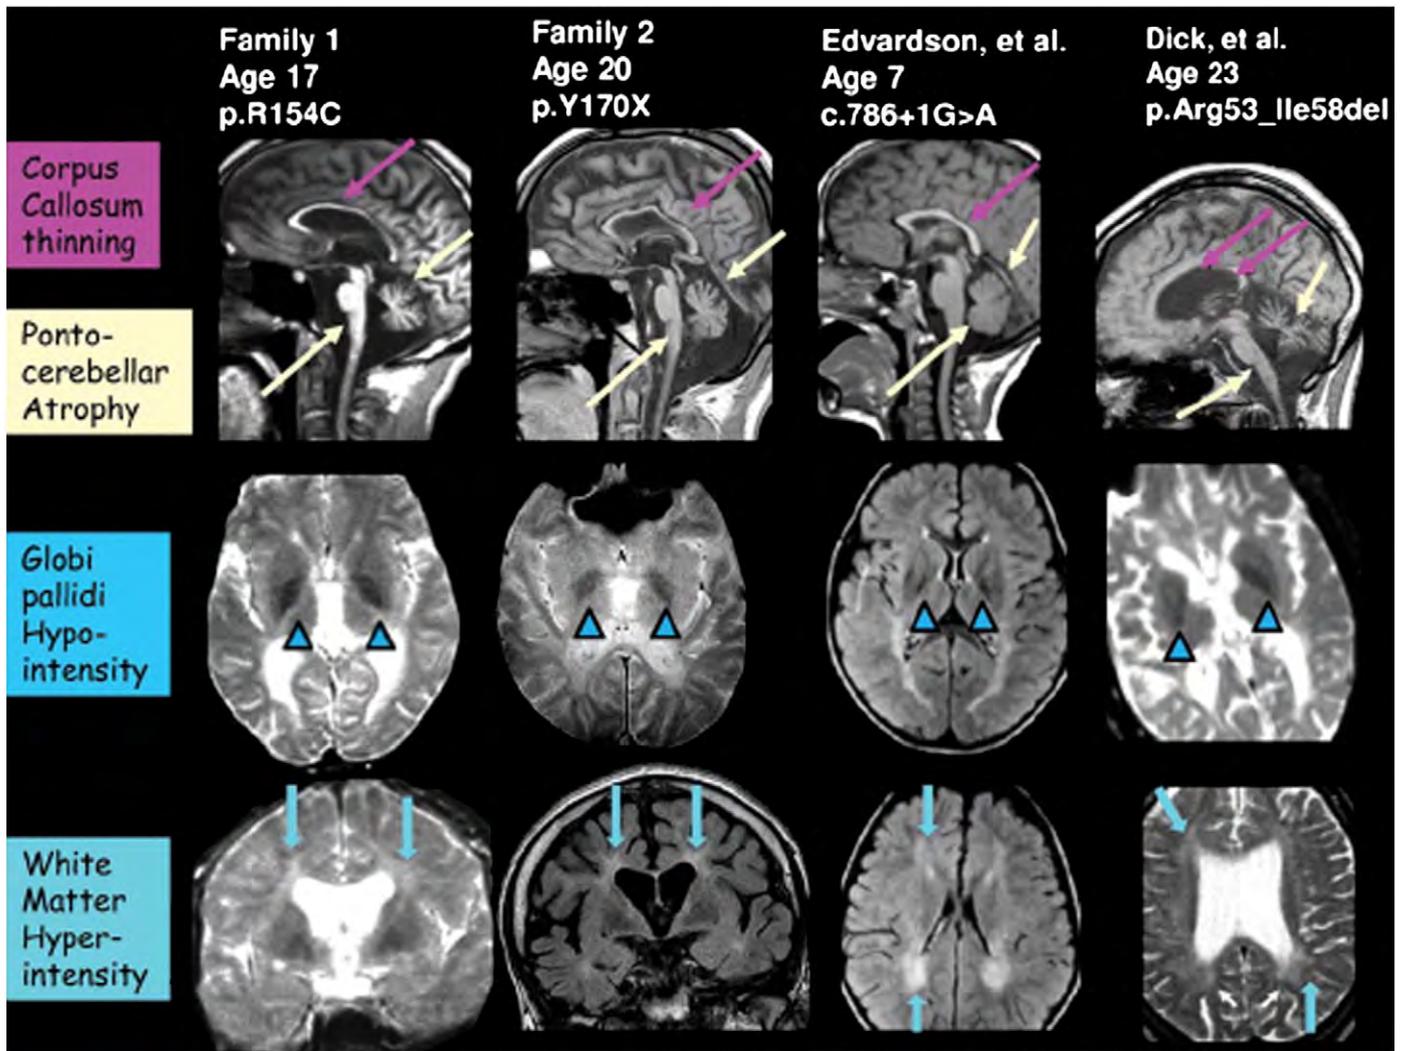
Fatty acid 2-hydroxylase associated neurodegeneration (FAHN). MR images of the brain from four published cases are depicted [70–72]. There is marked pontocerebellar atrophy (yellow arrows), mild cerebral atrophy, and thinning of the corpus callosum (magenta arrows) in all cases. T2-weighted images indicate hypointensities of the globus pallidus (arrowheads) consistent with iron deposition, and subcortical/periventricular white matter hyperintensities (blue arrows). Adapted from [70], with permission.
